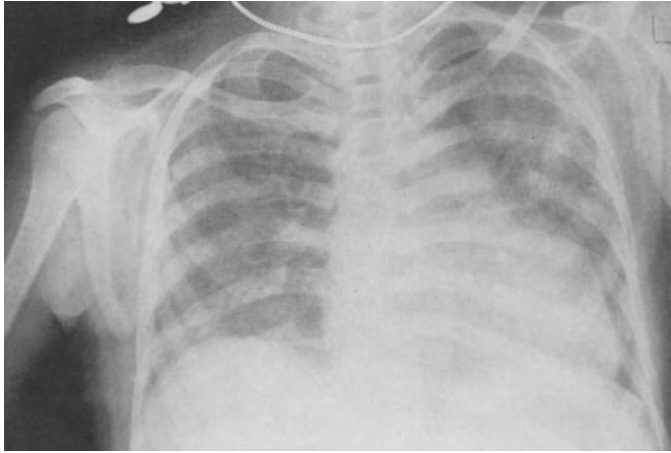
Chest roentgenogram of a young woman who died $4\frac{1}{2}$ months following renal transplantation in 1961. Cytomegalovirus was found at autopsy shortly after this picture was obtained
